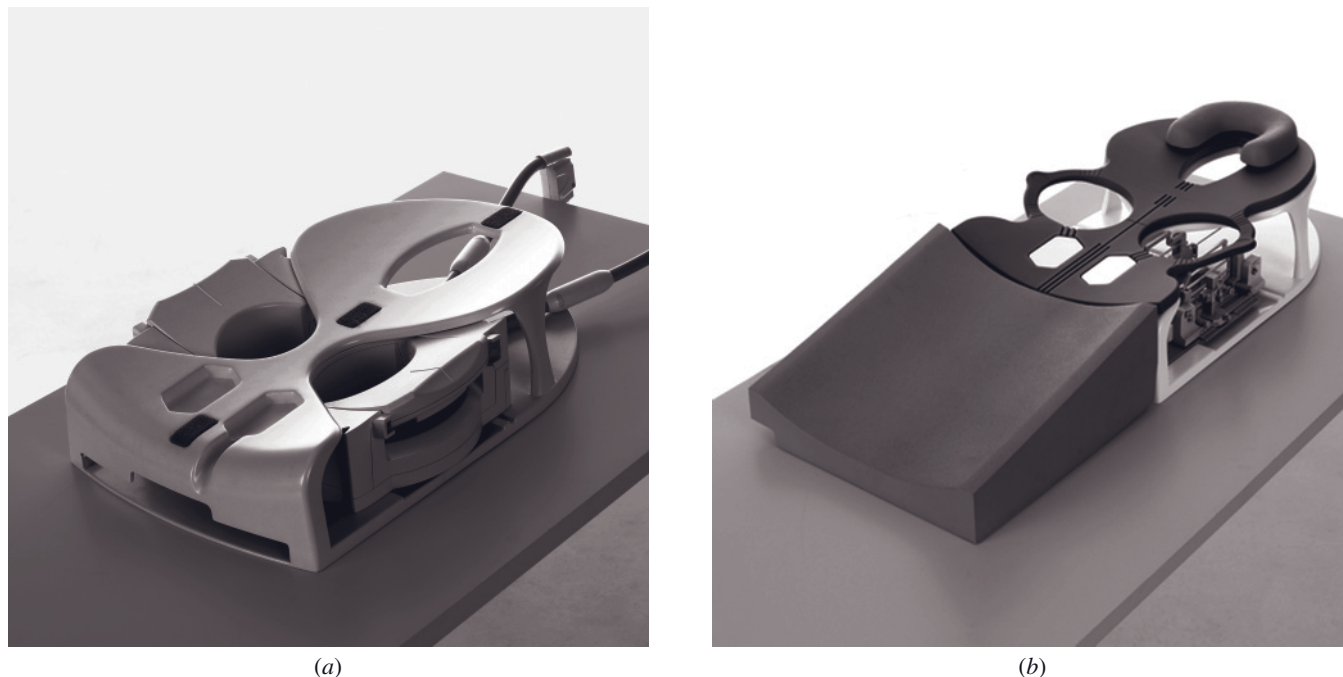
Dedicated open surface coils for breast MRI. A 16-channel dedicated breast coil is shown in *a*. The coil shown in *b* is used for both imaging and MR-guided interventions. There is a pillar-and-post type compression plate placed under the opening for the right breast.
